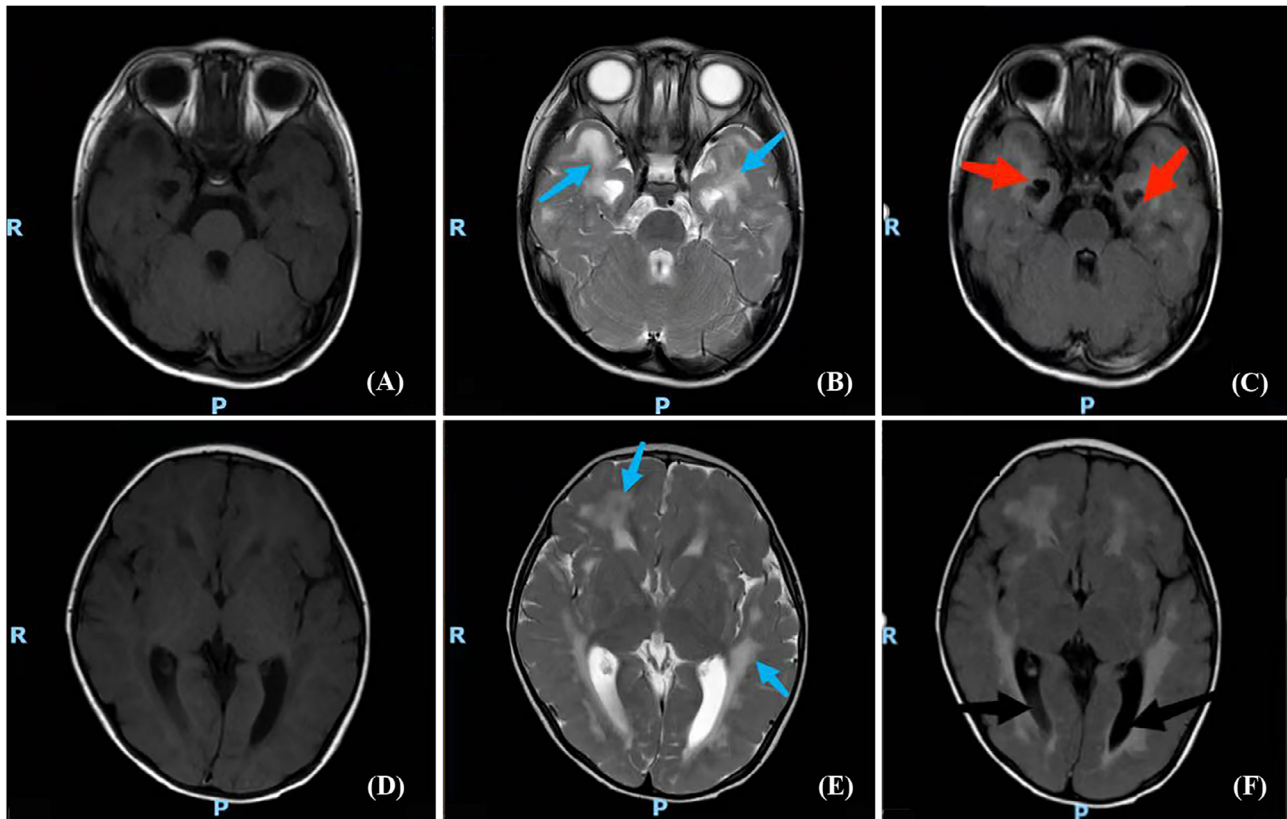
Magnetic resonance imaging (MRI) findings in Patient 6. Brain MRI showed bilateral white matter involvement in the cerebral hemisphere (blue arrows), ventriculomegaly (black arrows), and subependymal cyst in the temporal horn (red arrows). (A) and (D) showed axial T1-weighted images. (B) and (E) showed axial T2-weighted images. (C) and (F) showed Flair-weighted images.
